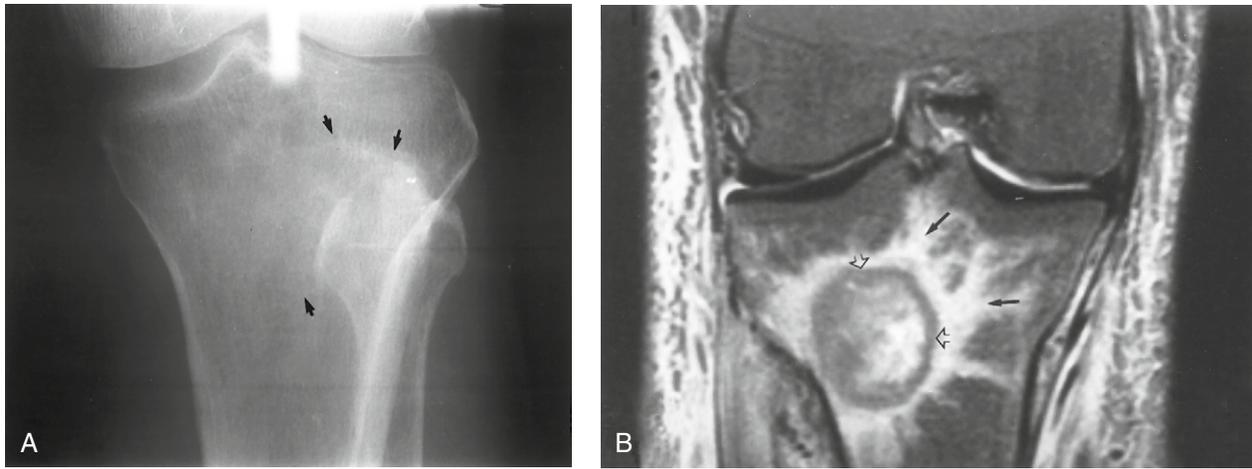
Aspergillus* osteomyelitis in a 60-year-old man with knee pain and history of renal transplant. (A) AP radiograph of the knee demonstrates an amorphous area of sclerosis without a definite lucency in the tibial metaphysis (arrows). (B) Coronal turbo short inversion recovery image (T2WI) shows a well-defined intermediate-intensity lesion with peripheral low intensity (open arrow). This low intensity corresponds to the sclerosis seen in the radiograph. Note the high-intensity marrow edema surrounding the lesion (long arrow). There is reversal of right and left on this image. (Reproduced with permission from Sonin et al.¹⁹³).
